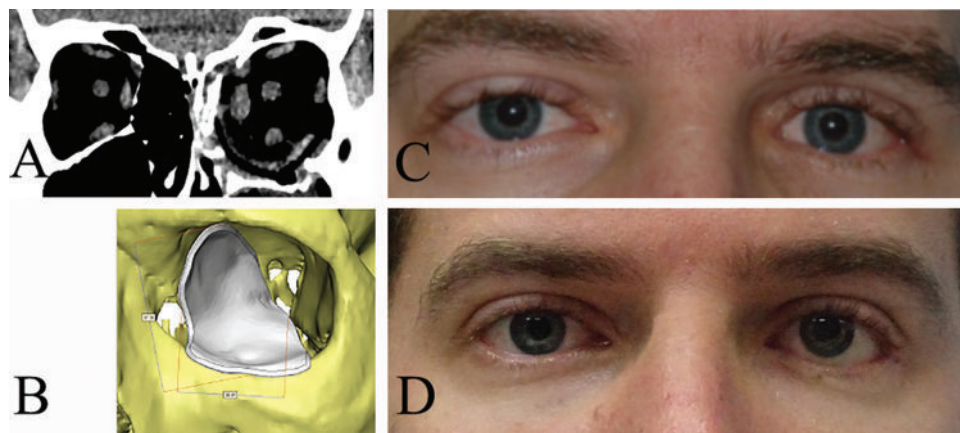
A. Postoperative coronal CT scan of a 30-year-old male who sustained a left orbital blow-out fracture with extensive floor and medial wall disruption during a baseball game. He underwent orbital fracture repair by a pre-formed implant (PFI). The implant can be seen situated on the orbital floor, but it does not bridge the full extent of the medial wall fracture, resulting in implant malposition and marked postoperative enophthalmos. B. Custom-made implant design based on the post-initial surgery scans. C. Image prior to patient-specific implant (PSI) surgery. D. Three months post-PSI surgery showing marked improvement in enophthalmos but lower eyelid retraction.
